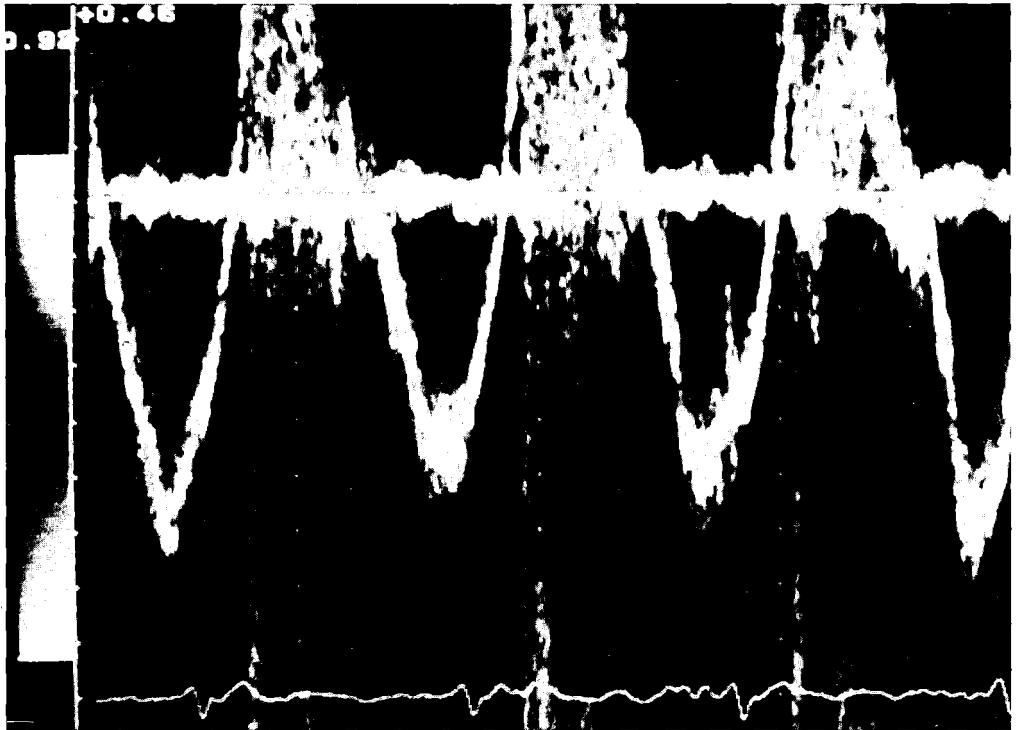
Transesophageal pulsed wave Doppler study for the immediate exclusion of tricuspid inflow obstruction after surgical reconstruction of Ebstein's malformation of the tricuspid valve. Maximal velocities are less than 1 m/s. There is mild tricuspid regurgitation.
